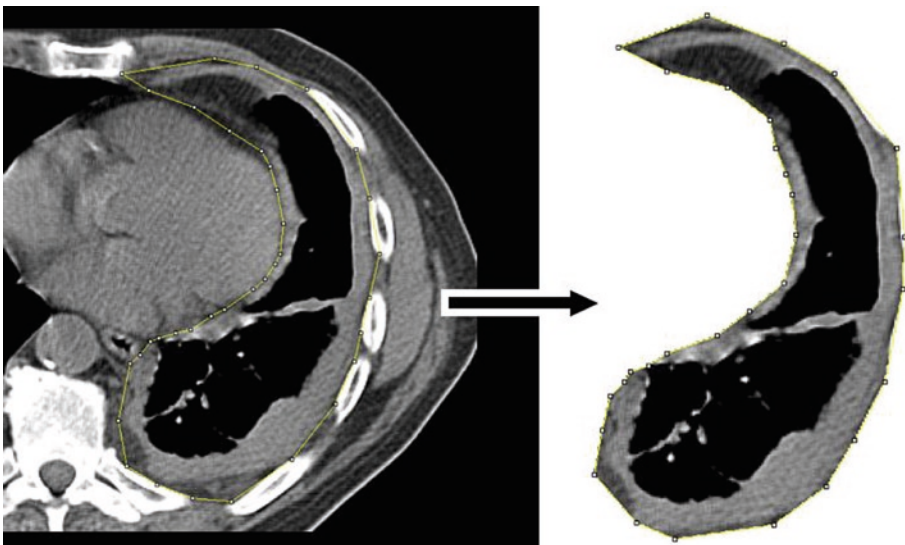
Volumetric assessment of tumor using Image J to segment pleural tumor from CT DICOM data and calculating overall tumor volume from axial images
